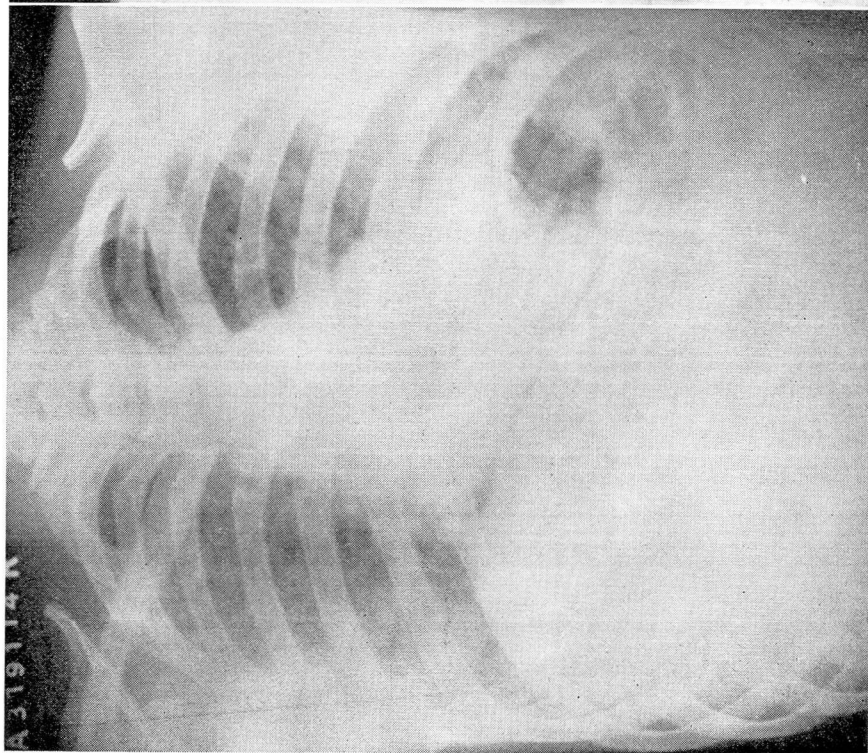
This chest represents the changes at the height of the disease. The roentgen film shows a diffuse soft patchy infiltration in both lungs with prominence of the peribronchial markings and a little elevation of both diaphragms.
